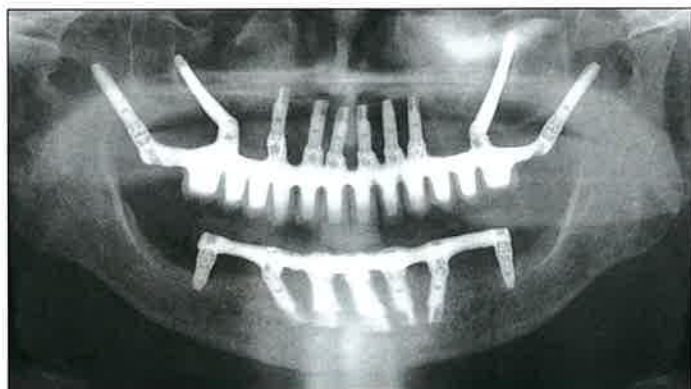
Panoramic radiograph obtained following delivery of definitive CM Bridge prosthesis (milled titanium).
